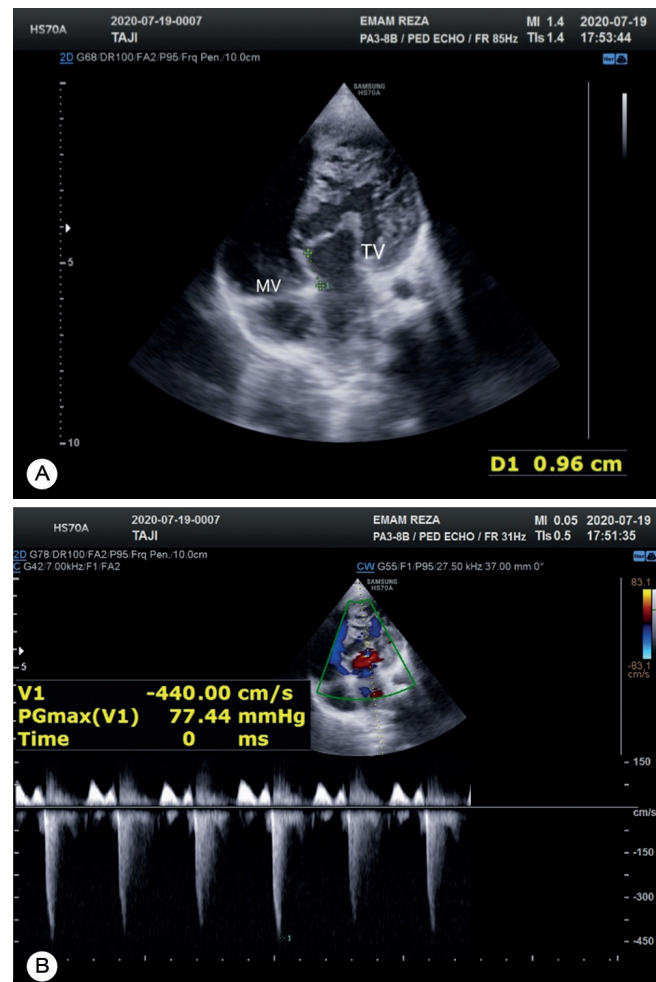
A) The apical 4-chamber view shows characteristic Ebstein's anomaly with the displacement of the tricuspid valve. Additionally, a markedly hypertrophic morphological right ventricle is seen on the left side. B) Continuous-wave Doppler imaging of the tricuspid valve displays a peak gradient of 77.44 mmHg.
